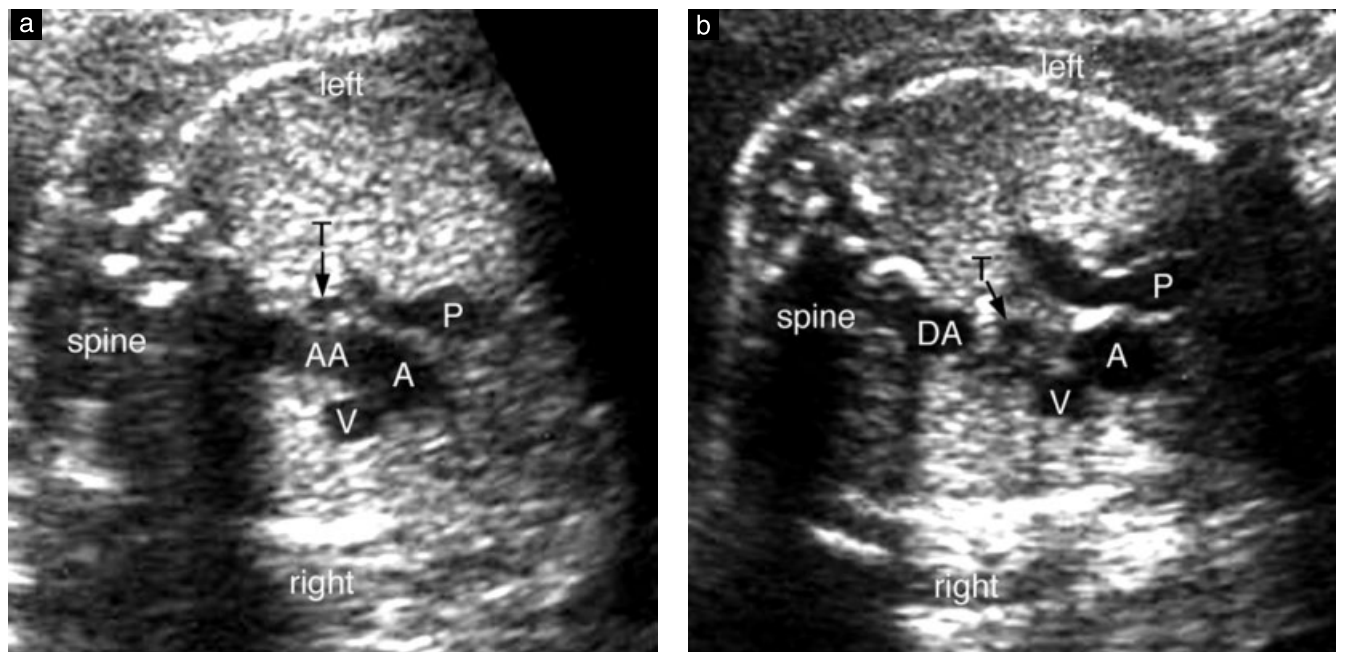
Right aortic arch (AA). (a) Transverse sonogram through the aortic arch shows that it is on the right side of the trachea (T). (b) Three-vessel view shows that the descending aorta (DA) is on the right side. A, ascending (ventral) aorta; P, main pulmonary artery; V, superior vena cava.
